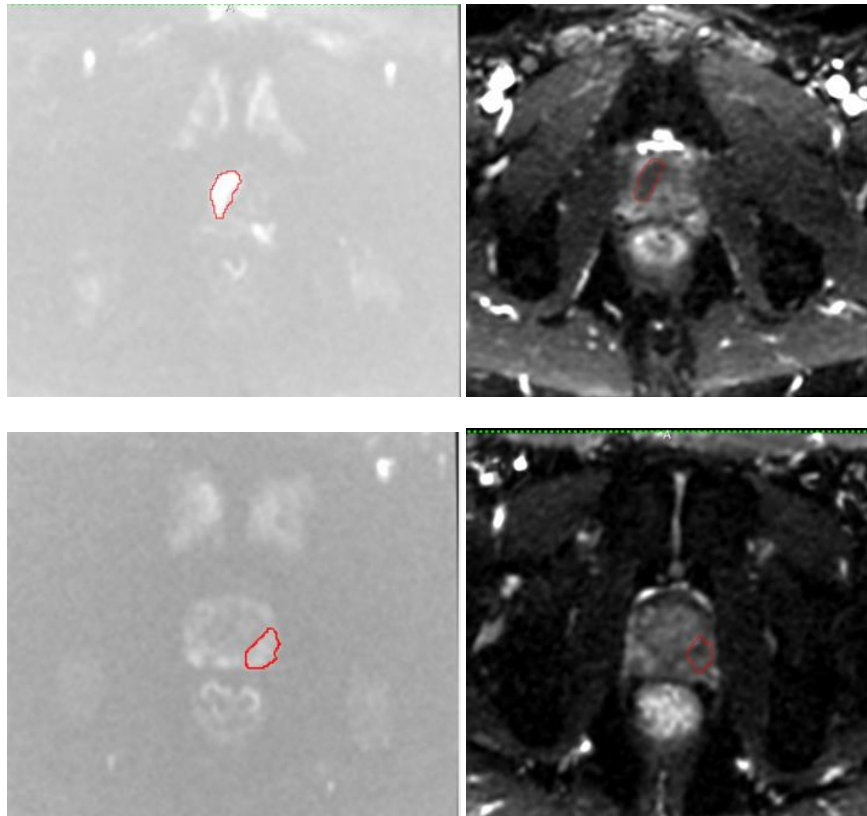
Index lesions delineated on DW-MRI (left panels) and ADC (right panels).
